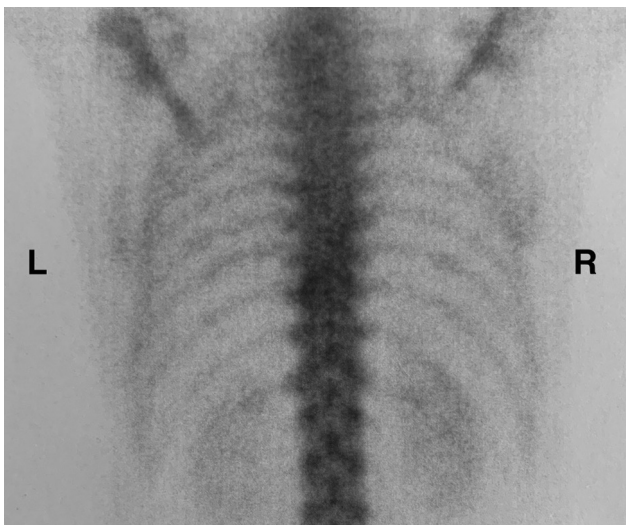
Bone scintigraphy marked with Tc-99m. Isolated hyperuptake at the level of the 10th left costovertebral joint (L- left side; R-right side).
